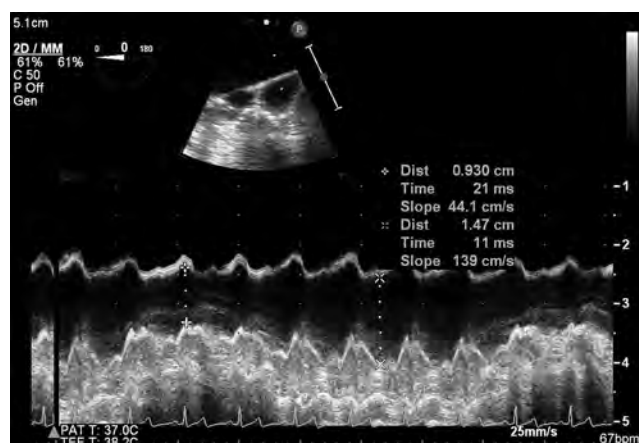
Ascending aorta short-axis echocardiographic view. The right pulmonary artery is at the top of the screen. The superior vena cava is in the short axis beneath it. Note the collapsibility with positive-pressure ventilation.
